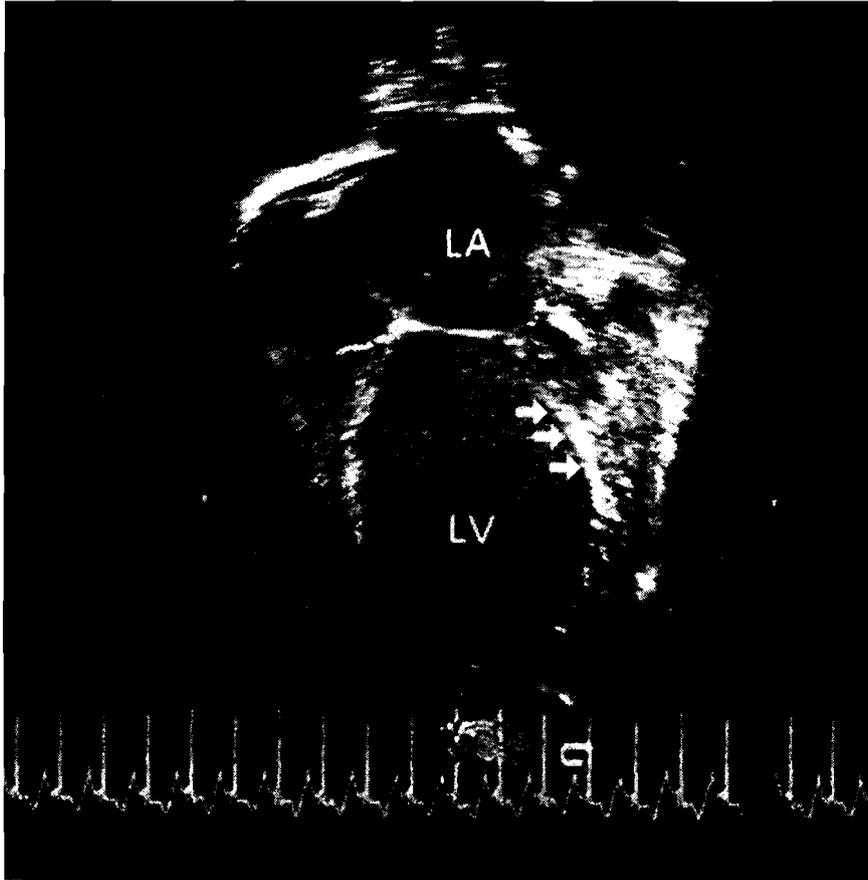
Two-dimensional echocardiographic image from a four-chamber view in an infant who has anomalous origin of the left coronary artery from the pulmonary artery and resultant dilated cardiomyopathy. There is dramatic dilatation of the left atrium (LA) and left ventricle (LV) with echobright, fibrotic changes of the mitral papillary muscles (arrows) secondary to chronic left ventricular ischemia.
